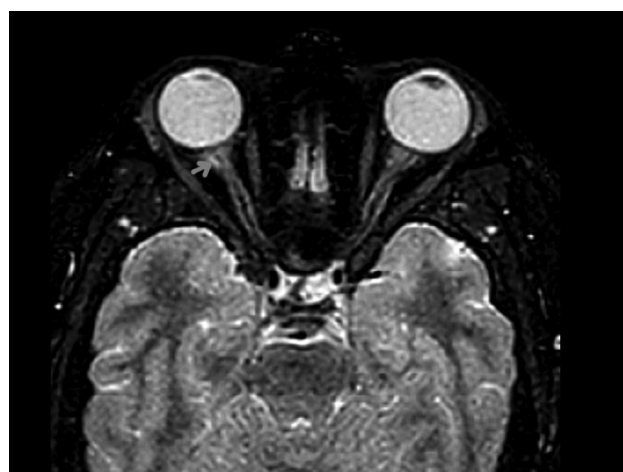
Orbital magnetic resonance imaging (MRI) in axial STIR sequence. A focal hyperintensity (arrow) is observed along the retrobulbar segment of the right optic nerve. The left optic nerve demonstrates normal signal.
